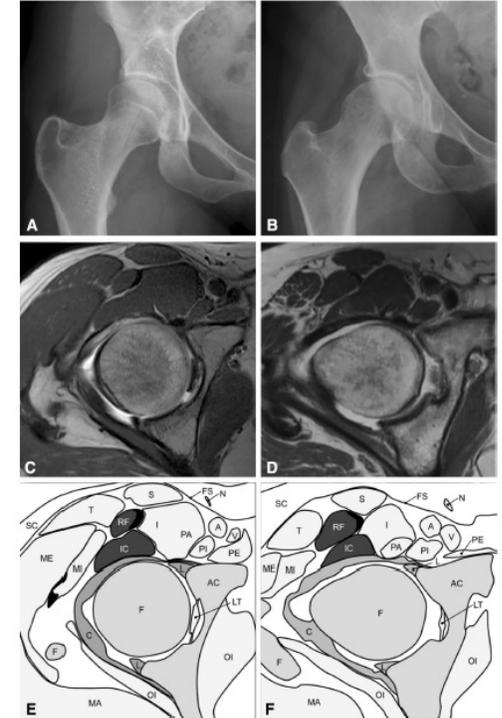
Radiographs of two hips (A–B) with comparable acetabular coverage and no clear predominant pathophysiological problem are shown. In the corresponding axial MRI slice, the ratio of iliocapsularis (IC) to rectus femoris (RF) for the cross-sectional area is increased in the left hip (C) and slightly decreased in the right one (D). This indicates that DDH is the predominant pathophysiology in the hip on the left (E), whereas acetabular coverage seems not to be insufficient in the other hip (F). F = femoral head; AC = acetabulum; L = labrum; LT = transversum ligament; MA = gluteus maximus; ME = gluteus medius; MI = gluteus minimus; T = tensor fasciae latae; S = sartorius; I = iliacus; PA = psoas major; PI = psoas minor; PE = pectineus; OI = obturator internus; A = femoral artery; V = femoral vein; N = femoral nerve; FS = superficial fascia; SC = subcutaneous fatty tissue.
